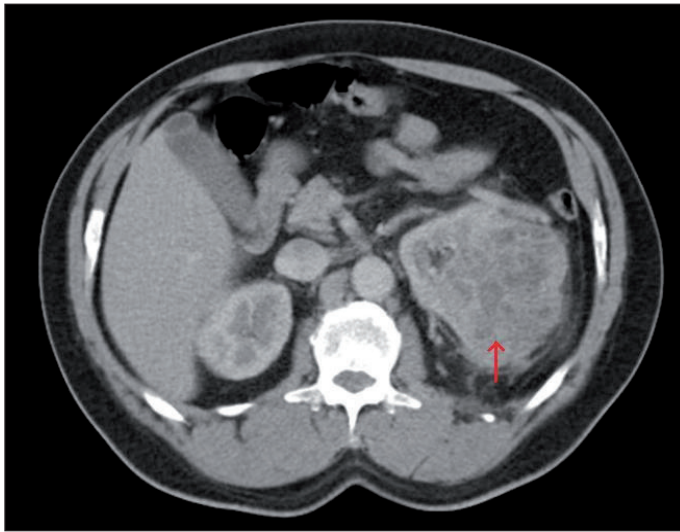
Computed tomography showing nonuniform masses originating from the lateral cortex of the left kidney.
